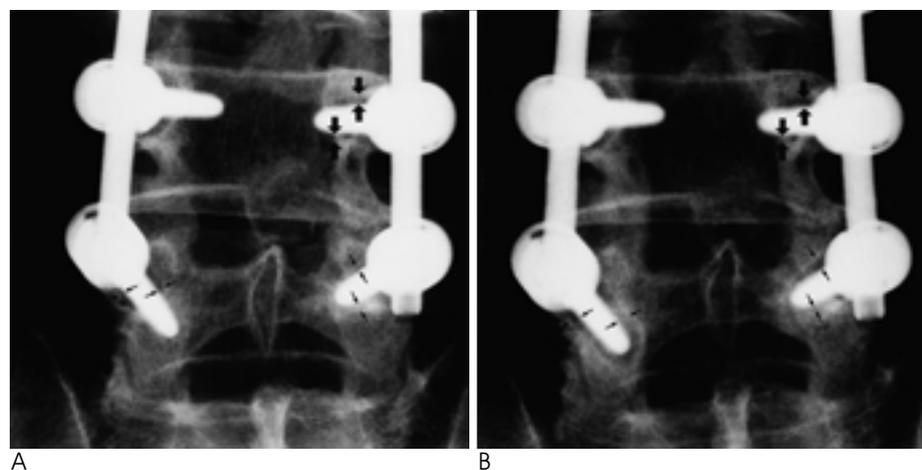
Progression of bone resorption (A) AP radiograph of bone resorption (62-year-old man). Grade 1 bone resorption in L5 (between thin arrows) and grade 2 bone resorption in L4 (between thick arrows) are noted. (B) AP radiograph of the same patient obtained 7 months later. Progression of bone resorption in L5 to grade 2 (between thin arrows). The grade 2 bone resorption in L4 remained stable (between thick arrows).
